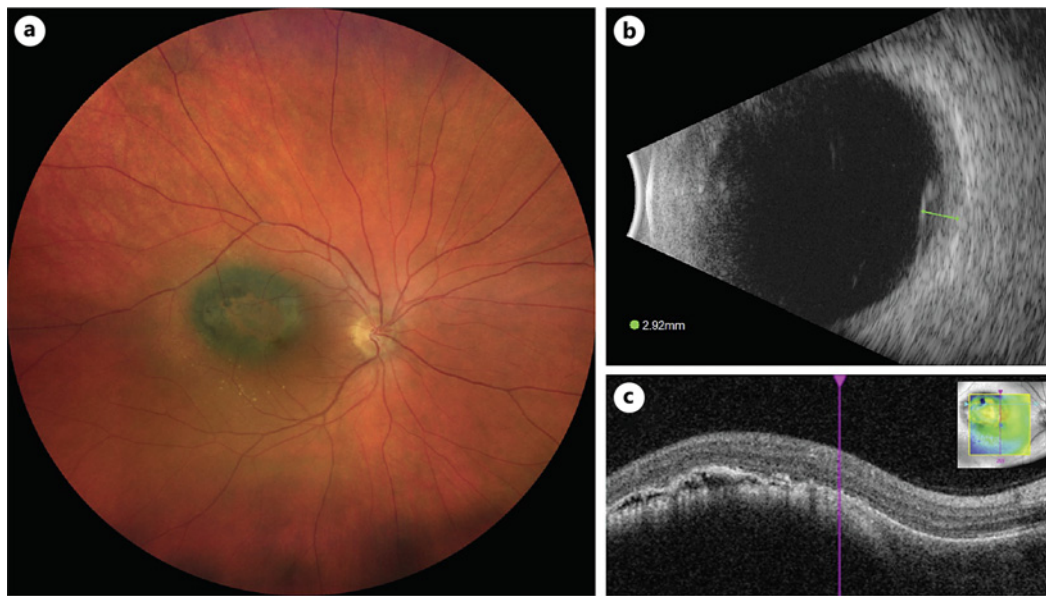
Choroidal tumor in the right eye at presentation. a Fundus examination revealed a pigmented lesion with orange pigment in the supratemporal macula. b A B-scan ultrasound exam showed an apical height of 2.92 mm. c Subretinal fluid in the projection of the tumor was detected on OCT.
